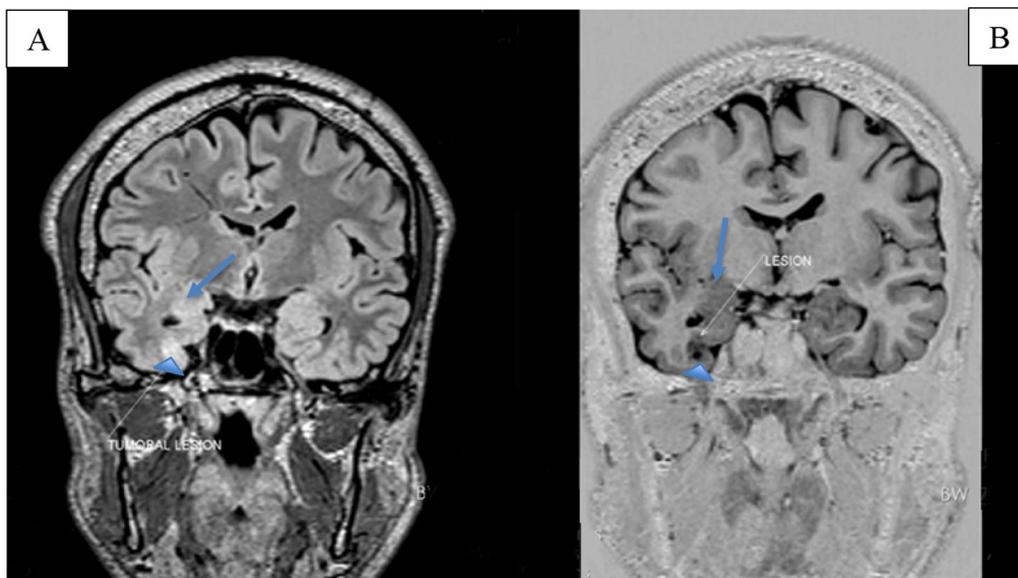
A, B Brain magnetic resonance imaging coronal views show typical findings of hippocampal sclerosis on right as hippocampal atrophy (A, B) and increased Flair signal (A-arrow) and a heterogeneous lesion on the right parahippocampal gyrus suggesting low-grade glioma as increased Flair signal (A-arrow head) with an intracranial cystic component (B-arrow head)
